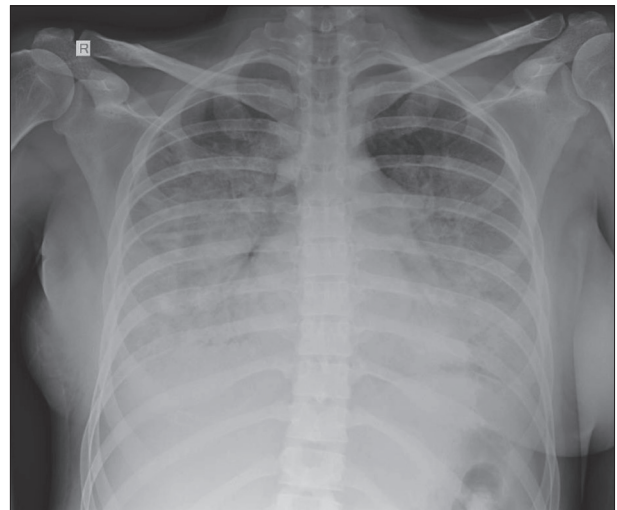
X-ray of the patient's heart and lungs a day after the administration of two doses of tocilizumab; lung fields on both sides with persistent diffuse shadowing, more extensive compared to the previous finding
